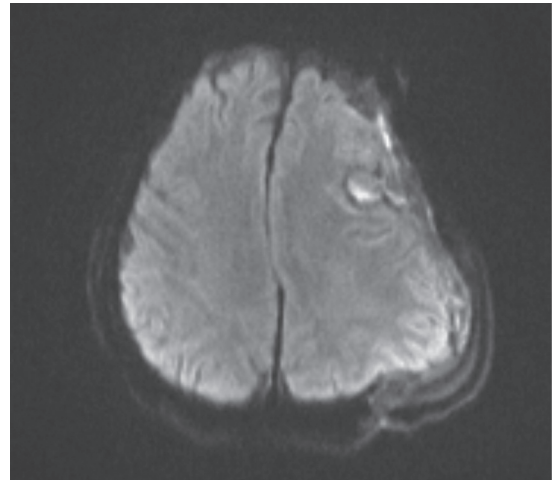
Brain MRI paradoxical brain herniation
